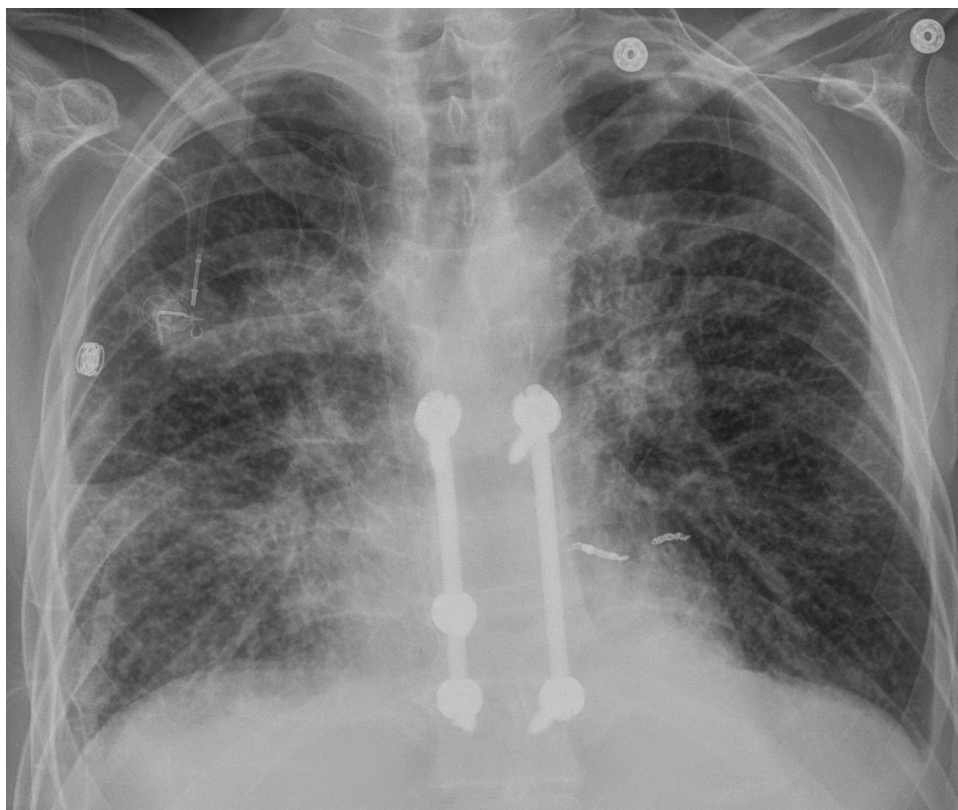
Chest radiograph with posteroanterior view diffuse bilateral interstitial prominence, left upper lobe cavitary lesion, and right upper lung airspace disease.
